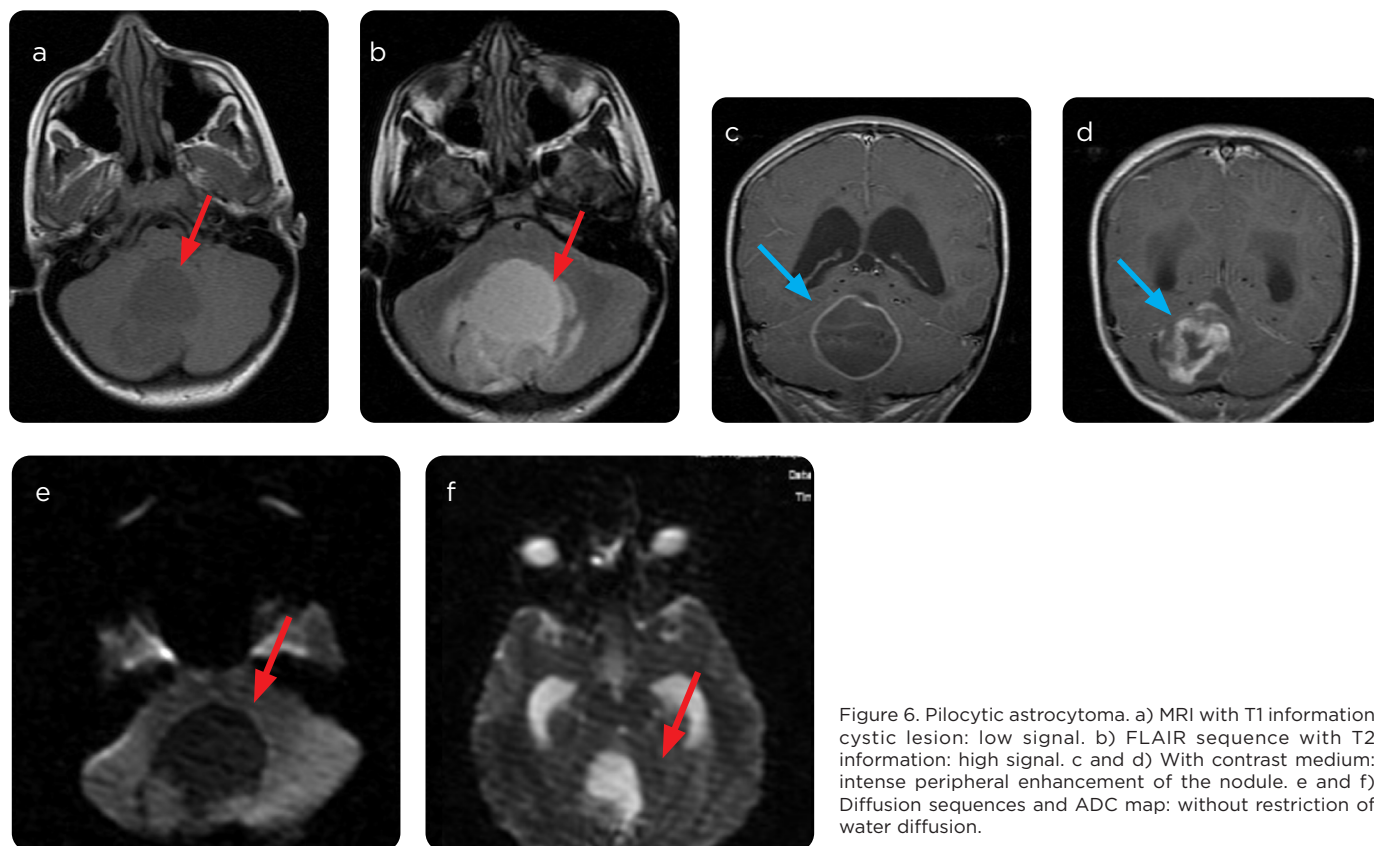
Pilocytic astrocytoma. a) MRI with T1 information cystic lesion: low signal. b) FLAIR sequence with T2 information: high signal. c and d) With contrast medium: intense peripheral enhancement of the nodule. e and f) Diffusion sequences and ADC map: without restriction of water diffusion.
